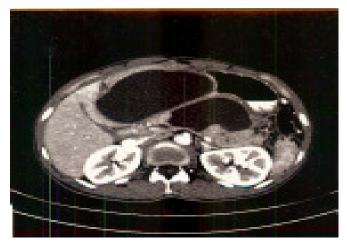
Contrast enhanced CT scan of the abdomen showing pancreatic transection and acute fluid collection.
